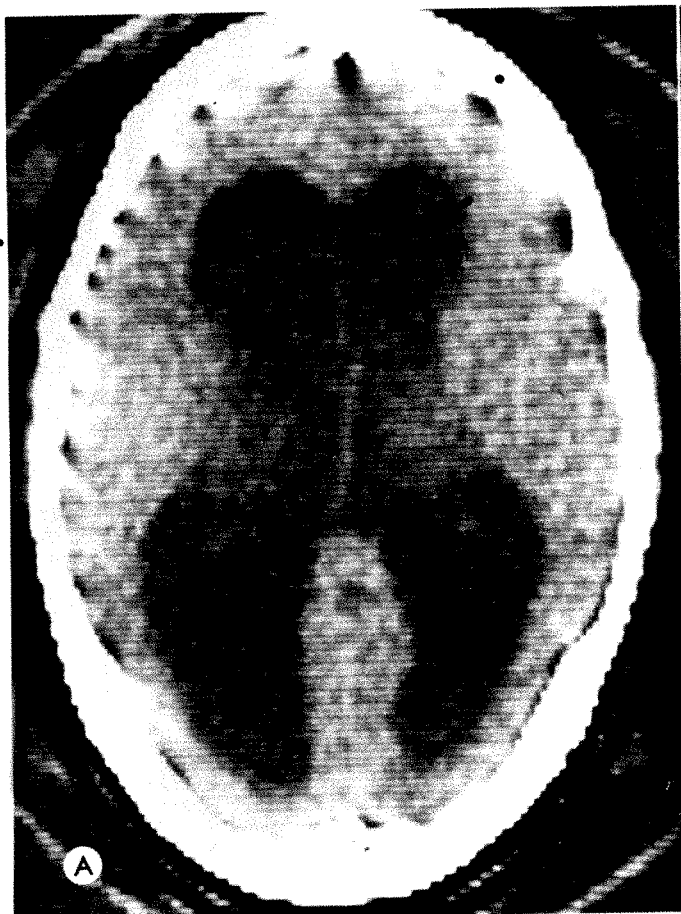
Ventriculitis. 30-year-old woman who developed *Staphylococcus coagulase* ventriculitis after shunt procedure for treatment of aqueductal stenosis, followed by *Klebsiella* ventriculitis. Both lateral ventricles were shunted after Conray ventriculogram revealed obstruction of both foramina of Monro. Patient did not respond to therapy and expired. A, CT scan prior to initial shunt procedure revealing marked hydrocephalus. B, Scan after development of infection revealing hydrocephalus and material of higher density than CSF occupying both occipital horns (cf. fig. 12A). At autopsy, this was found to be pus material and necrotic debris. C, Brain section demonstrating location of infection in dependent occipital horns. Note lack of irregularity of occipital horns (cf. fig. 13.) Bacterial infection does not lead to subependymal gliosis.
